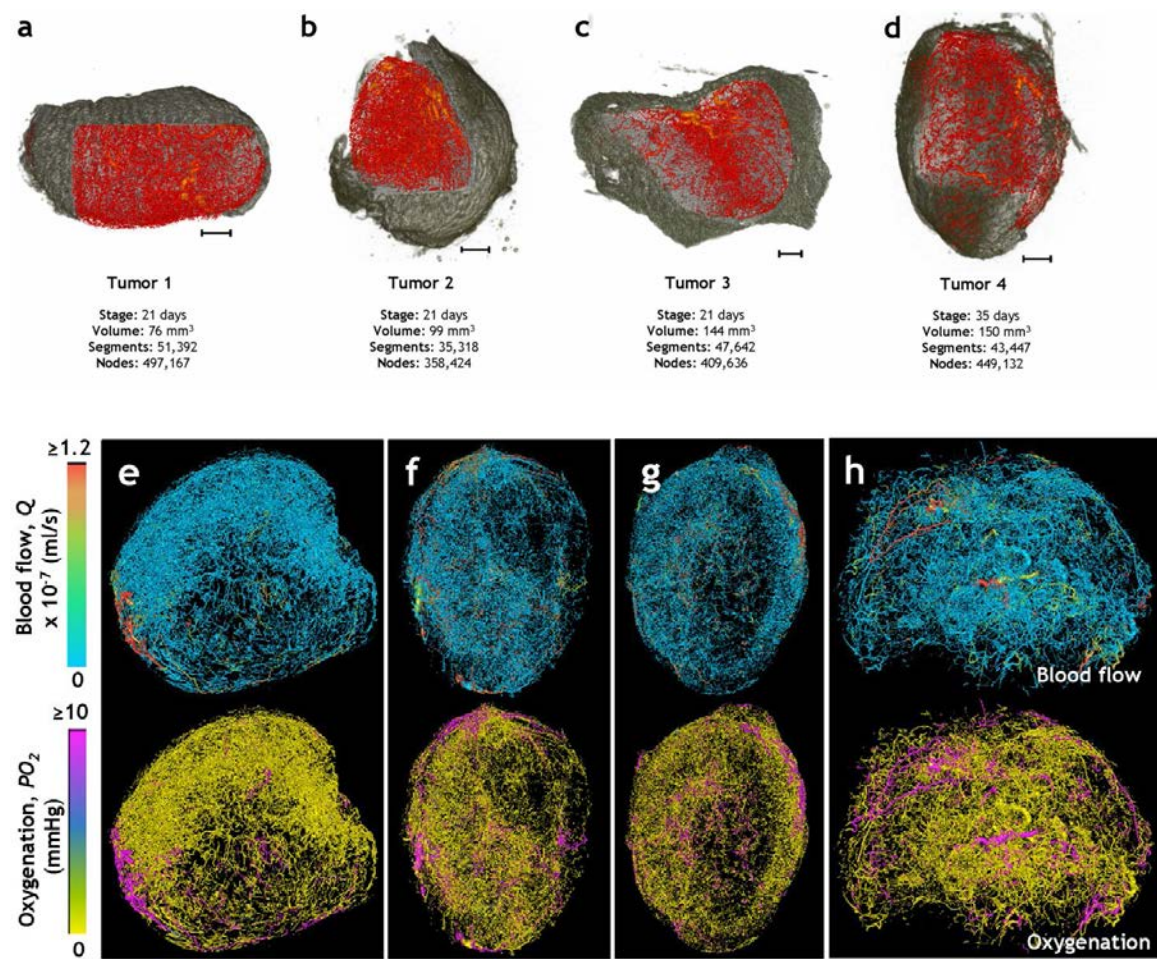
Images adapted with permission from Stamatos and Bhargava, et. al 2019. Top row: an ensemble of four tumors with the MRI-derived soft tissue and CT-derived blood vessels color coded by vessel diameter. Bottom row: an ensemble of four other tumors with blood vessels color colored by their average blood flow rate (ml/s) (blue) and average intravascular oxygen tension (mm Hg) (gold). *Text not intended to be read.*
